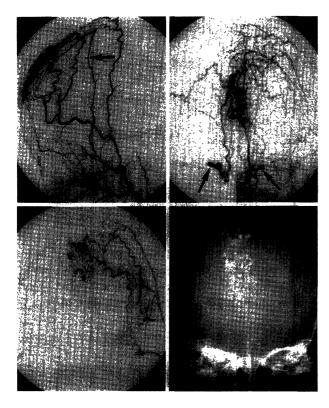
Case 3. upper left: Left external carotid arteriogram (lateral view) showing the scalp AVFs fed by the branches of the left STA and the left middle meningeal artery (arrow). upper right: Arteriogram (anteroposterior view, late arterial phase) showing the AVFs on the midline draining to the superficial scalp veins and the bilateral superior orbital veins (arrows). lower left: Post-embolization left superficial temporal arteriogram (anteroposterior view) showing the shunted flow is markedly reduced. lower right: Plain skull x-ray film (anteroposterior view) after embolization. The glue is located predominantly in the venous side of the AVFs as well as in the right STA.
